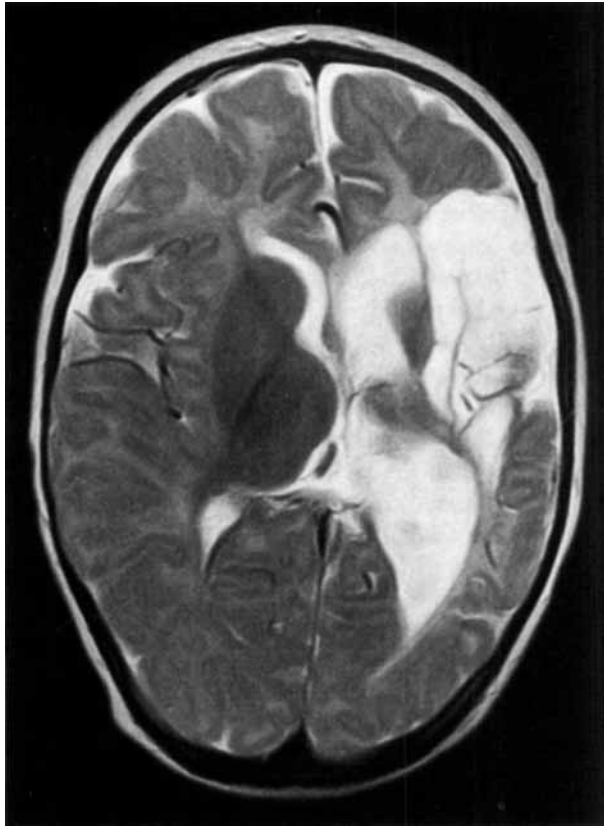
T2-weighted image showing atrophy with ex vacuo dilatation of the body of the lateral ventricle and gliosis in the left frontotemporal region without evidence of blood products. Imaging in other planes confirmed the absence of any communication with the body of the left lateral ventricle. A magnetic resonance angiogram performed concurrently revealed a small left middle cerebral artery.
